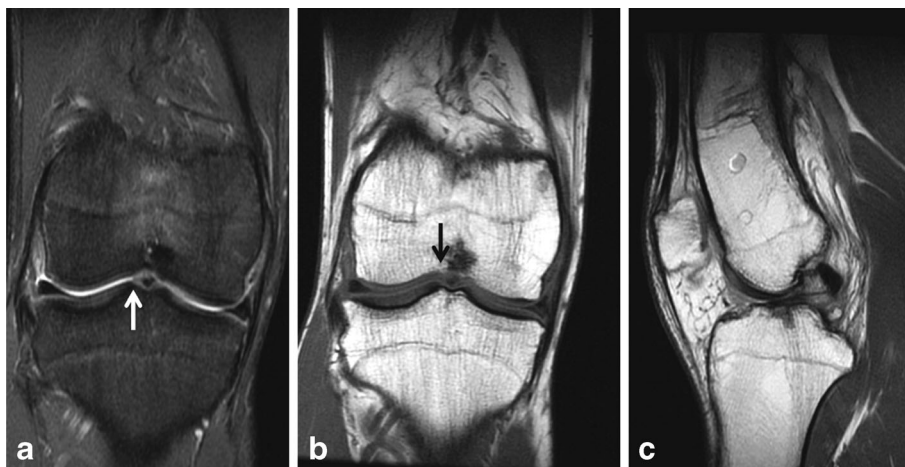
Magnetic resonance images. a Fat saturation coronal view. b T1 coronal view. c T1 sagittal view. There is an apparent absence of the ACL, hypoplasia of the tibial spines (*white arrow*), an extremely stenotic intercondylar notch, and a dysplastic femoral trochlea (*black arrow*).
